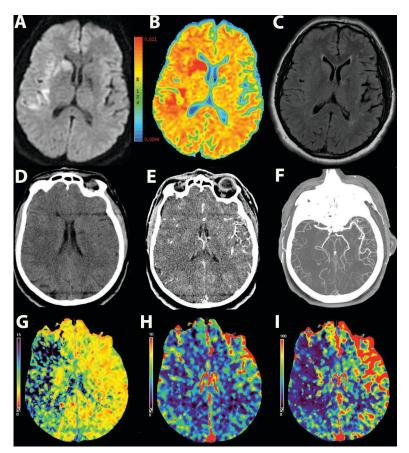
Case #1. Neuroimaging at admission. A-C. Magnetic-resonance imaging (MRI): A. Diffusion weighted imaging (DWI). B. The apparent diffusion coefficient (ADC) map. C. Fluid-attenuated inversion recovery (FLAIR). D-I. Computed tomography (CT) scans: D. Non-contrast CT. E. CT-angiography source images (CTASI). F. Maximal intensity projection (CT-angiography). G-I. CT-perfusion study: G. The mean transit time (MTT) map. H. The cerebral blood volume (CBV) map. I. The cerebral blood flow (CBF) map.
